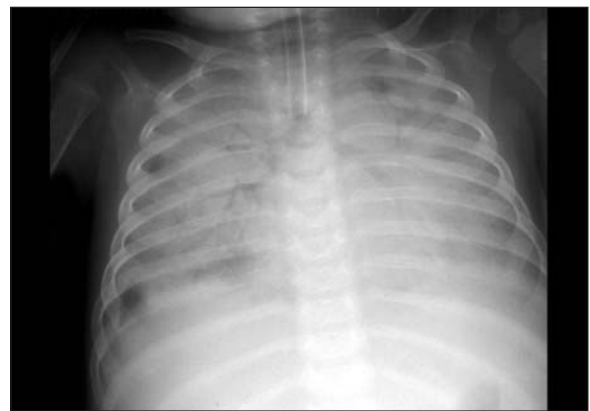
Bilateral infiltration of the lungs, air bronchograms, and disappeared borders of the heart due to ARDS on chest X-ray (Case 1).
